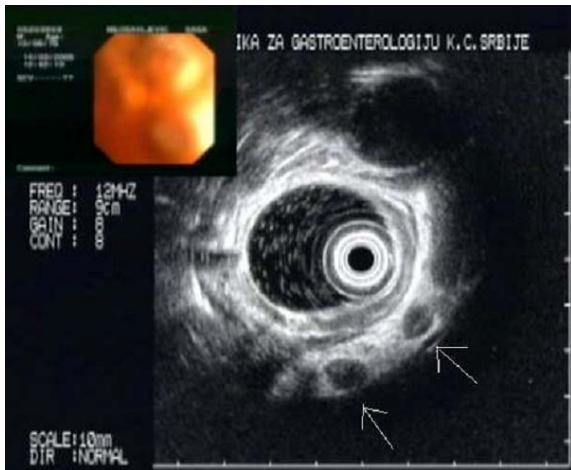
Ultrasound image of enlarged lymph nodes around the tumor (see white arrows)
